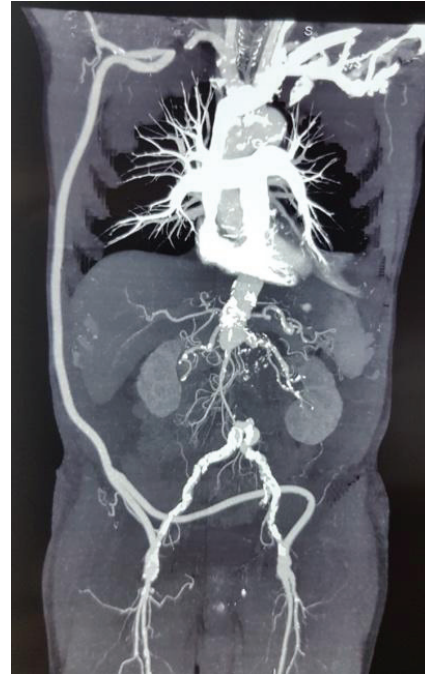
Multislice computed tomography angiography with patent axillo-bifemoral bypass and all visceral arteries, and with no liquid collections, gas or hematomas.
